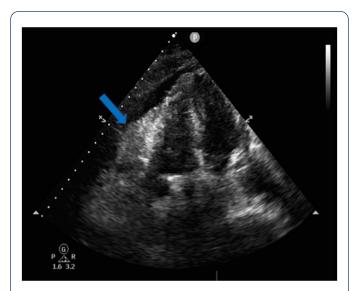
Apical 4 chamber view showing a large pericardial mass related to the right atrium and ventricle with mild pericardial effusion.
